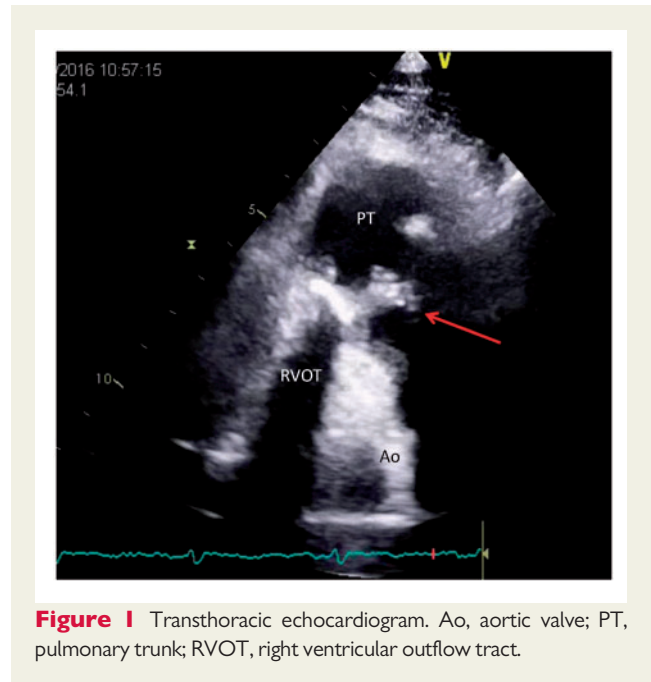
Transthoracic echocardiogram. Ao, aortic valve; PT, pulmonary trunk; RVOT, right ventricular outflow tract.
